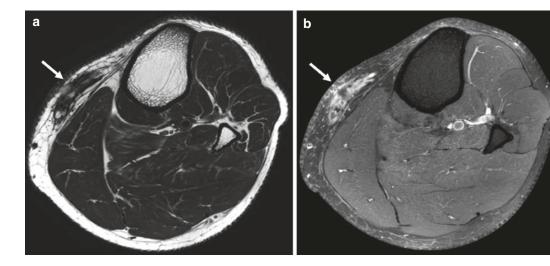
(a, b) Inadequate resection of pleomorphic sarcoma. (a) Axial T2-weighted and (b) fat-suppressed contrast-enhanced T1-weighted TSE images show an area of inhomogeneous signal intensity and contrast enhancement in the subcutaneous tissue of the lower leg without
